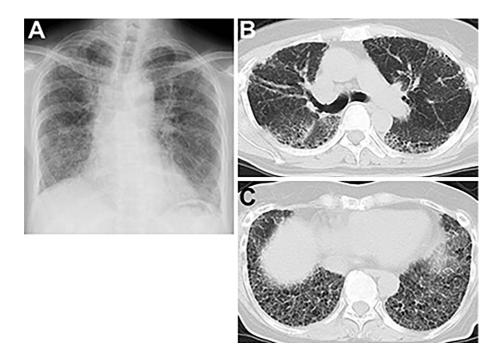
Imaging findings at the time of the patient's first visit to our hospital. (A) Chest radiography showed areas of reticular shadow and ground-glass opacity in the upper and lower lung fields, indicating a marked loss of lung volume (A). (B, C) Computed tomography revealed worsening of the ground-glass opacities and reticular shadows in the peripheral regions of the upper and lower lobes in both lungs. Traction bronchiectasis was noted, particularly in the right upper lobe, and honey-combing was noted in both lower lobes.
